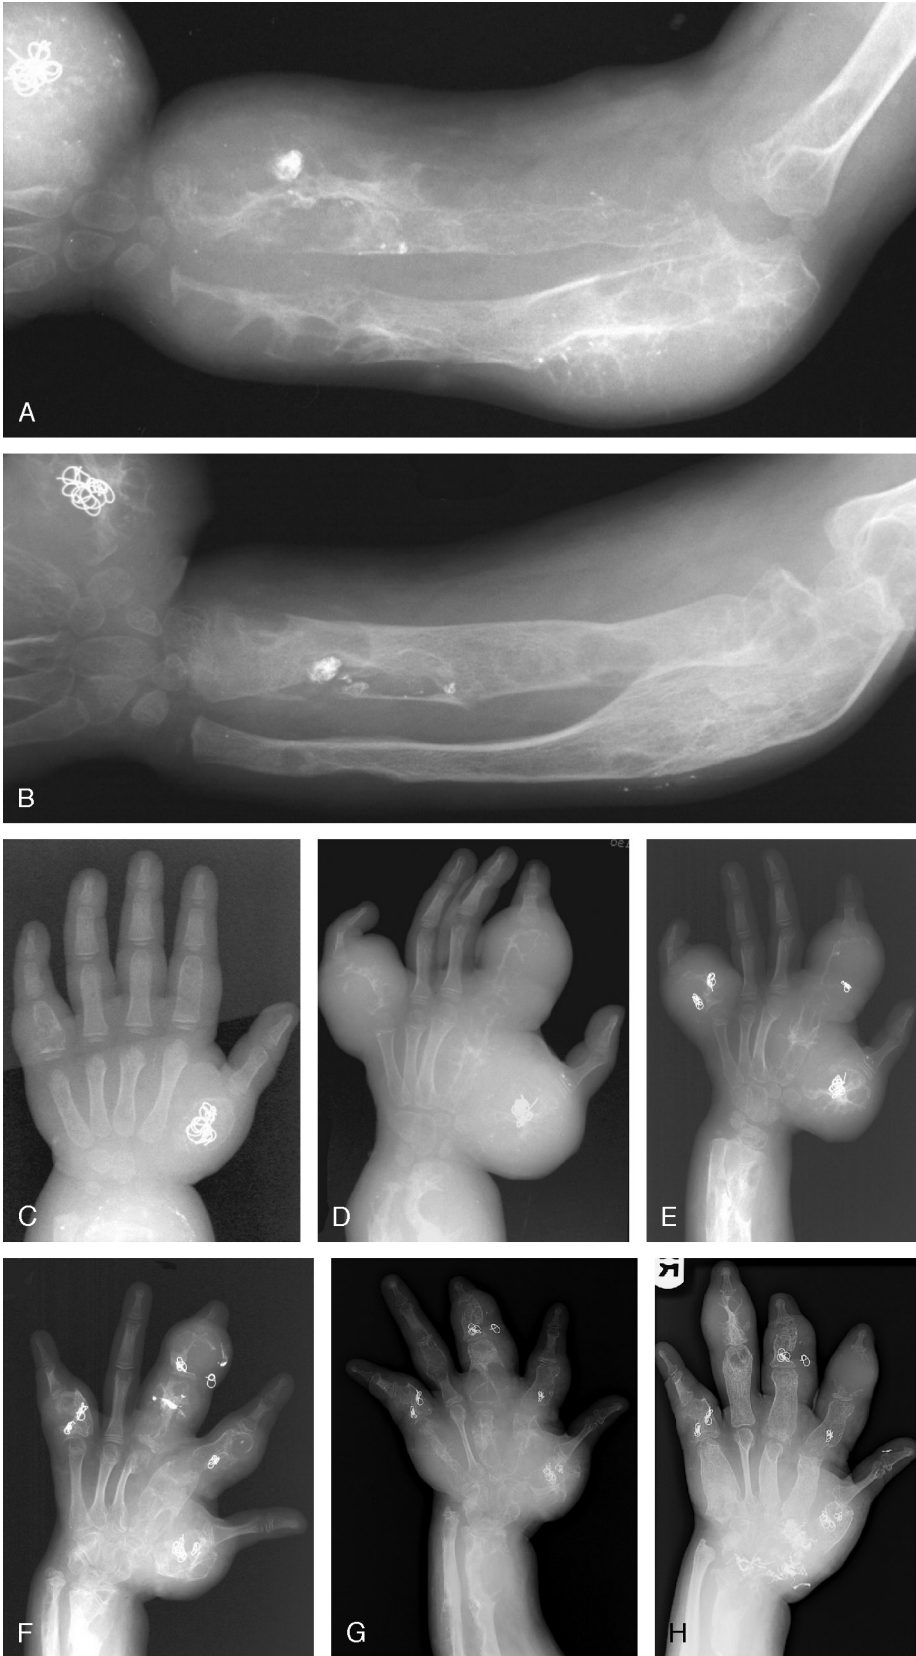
Serial radiographs of the patient's forearm and hand. Marimastat was started in July 1996. The metallic coils were introduced percutaneously into the varices draining the focal shunts. The images have been edited to correspond to the orientation of the clinical photographs. A, Radiograph of the radius and ulna in July 1996, immediately before starting marimastat, shows severe bony destructive changes and soft tissue swelling. Radiopacities represent residual opacified NBCA, most of which had been resorbed. B, Radiograph of the radius and ulna in 1998, after 2 years of marimastat, shows definite evidence of bone healing and remodeling. C–H, Radiographs of the right hand in 1995 (C), 1996 (D), 1998 (E), 2002 (F), 2006 (G), and 2008 (H). The final radiograph (H) shows healing of most of the lytic defects, but a new one has formed in the distal phalanx of the index finger.
